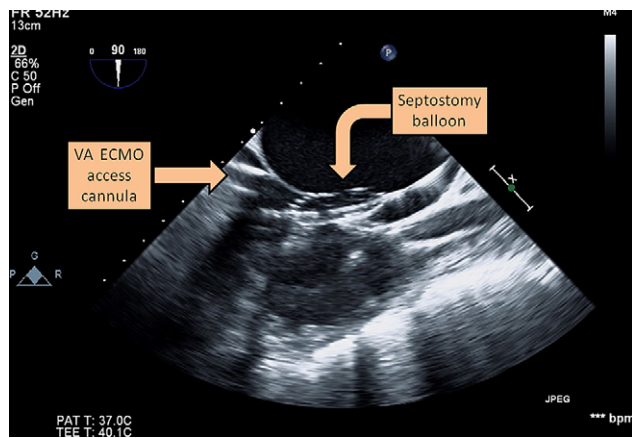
Septostomy balloon being inflated across the interventricular septum under transesophageal echocardiographic guidance.
